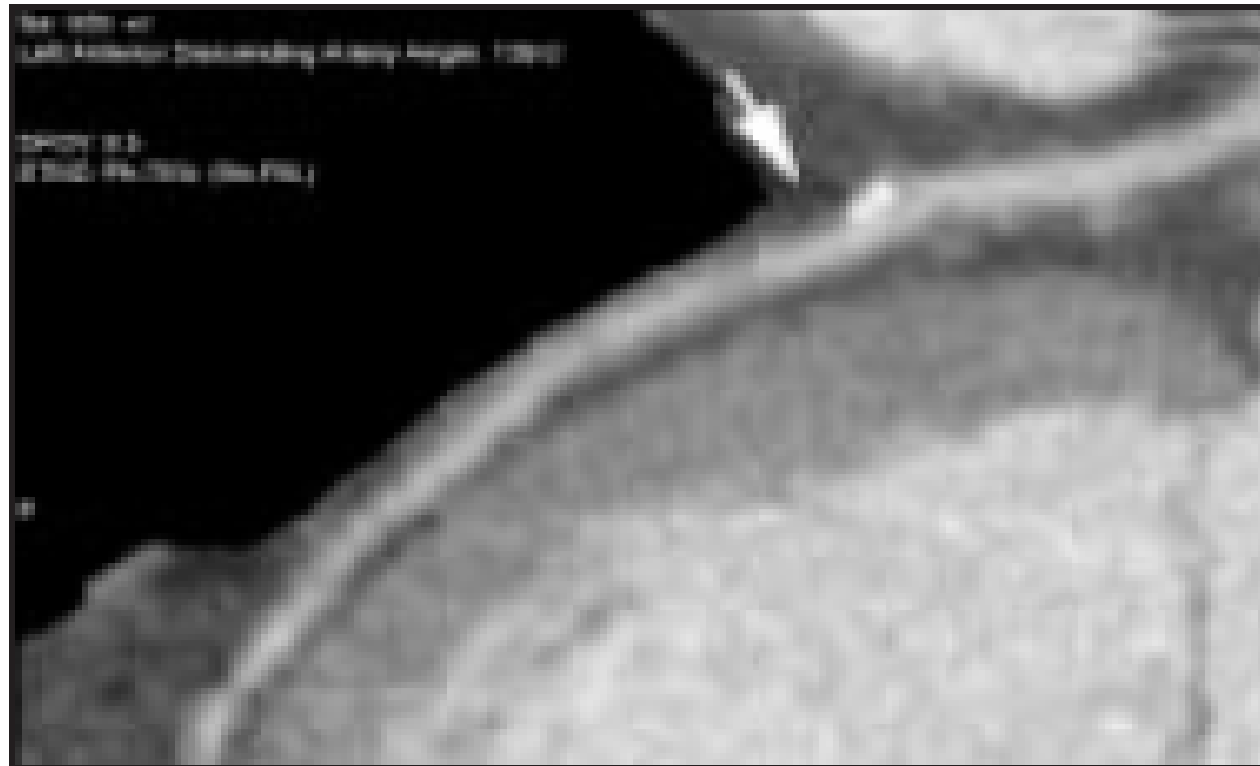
Stenosis (arrow) visualized in the left anterior descending artery by CTA. It consists of both calcified (bright white) and noncalcified (gray) plaque. The patient was asymptomatic and unaware that he had coronary artery disease.
